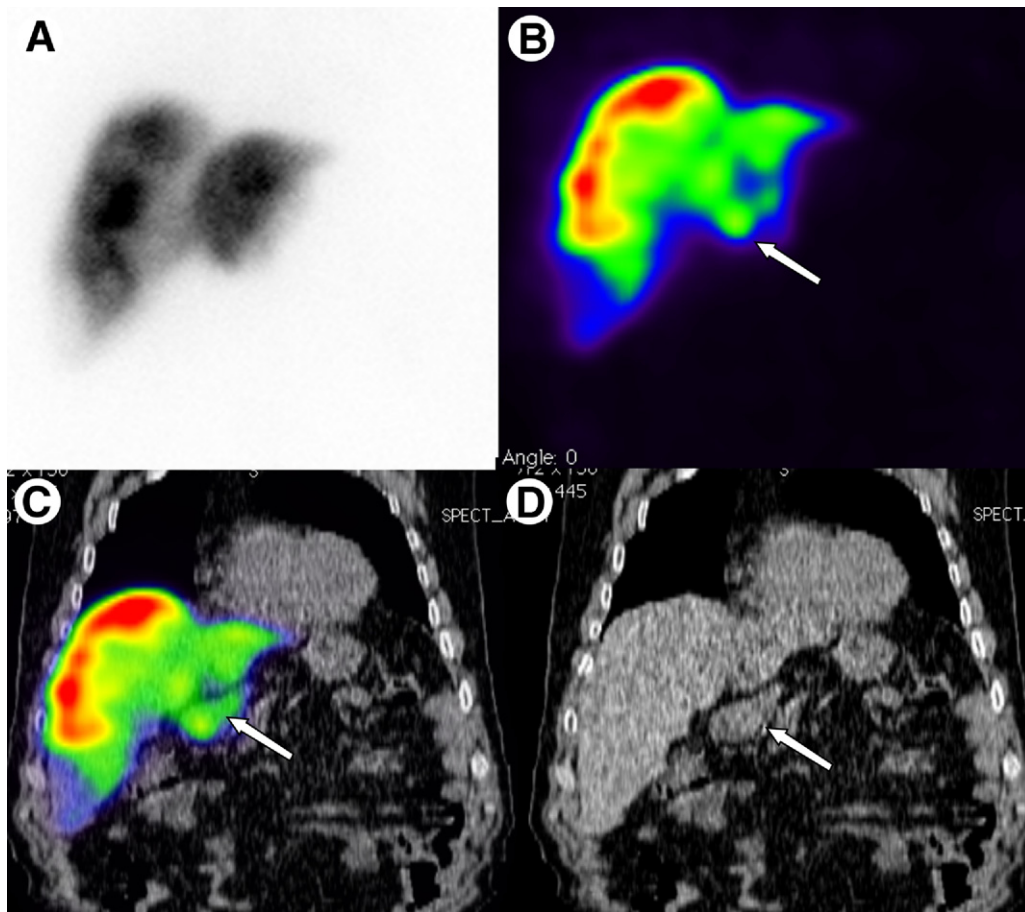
Duodenal accumulation (white arrow) in a patient with colorectal cancer (CRC), not discernable in the planar scan. A second Tc-99m-labeled macroaggregated albumin examination performed after embolization of the suspected arteries for causing the duodenal tracer accumulation showed no longer abnormal extrahepatic tracer accumulation (not shown here). (A) planar scan, (B) single-photon emission computed tomography coronal view, (C) single-photon emission computed tomography/computed tomography (CT) coronal view, and (D) CT coronal view.
